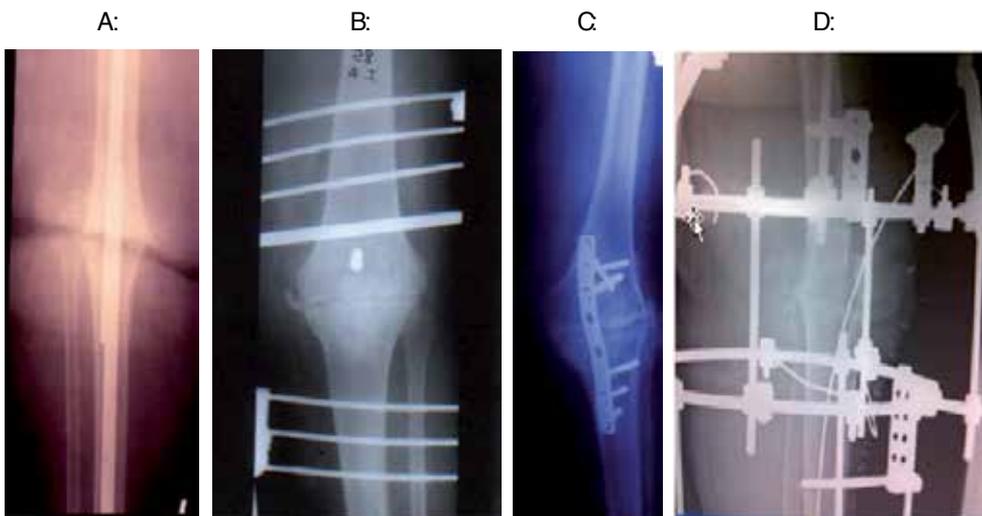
Radiographs of fused knees, following failed revision of TKA, by: A: Intramedullary nail, B: Tubular external fixator. C: Internal fixation by plate and screws, D: Ilizarov external fixator.
